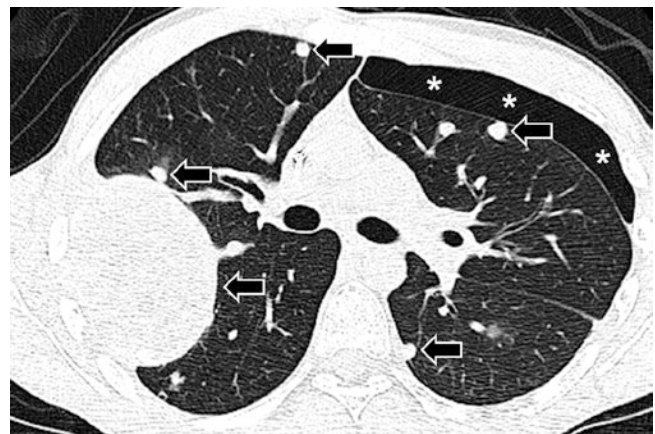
A 15-year-old boy with pneumothorax due to metastatic osteosarcoma. Axial lung window CT image shows multiple pulmonary metastasis (arrows) with pneumothorax (asterisks)
